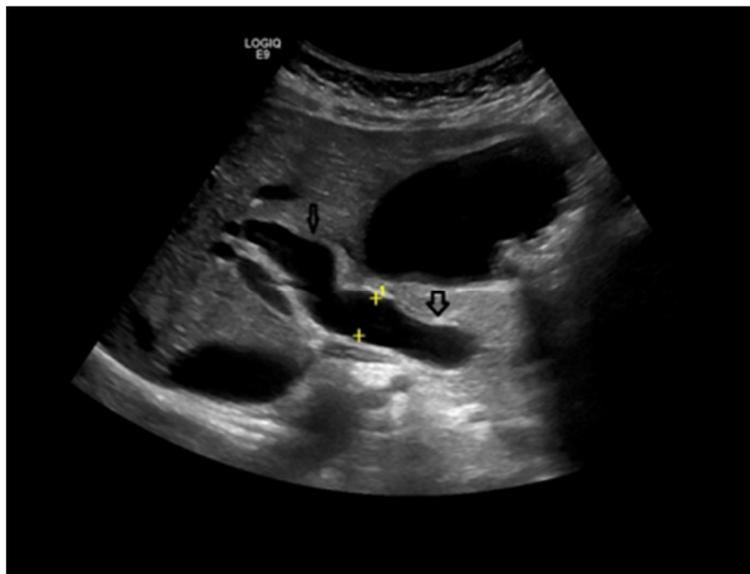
Standard ultrasound – obstructive jaundice. Wide choledocus-12 mm, thin-walled gallbladder, lithiasis with multiple small hyperechoic images with acoustic shadow cone
